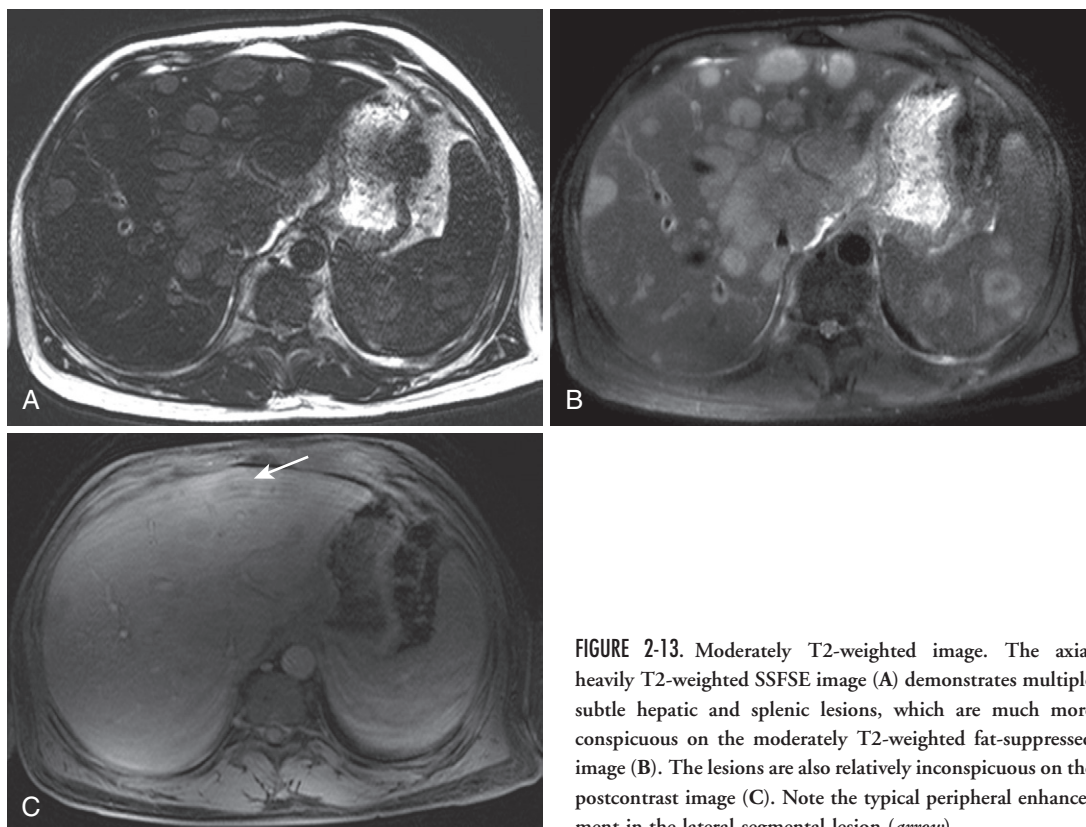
Moderately T2-weighted image. The axial heavily T2-weighted SSFSE image (A) demonstrates multiple subtle hepatic and splenic lesions, which are much more conspicuous on the moderately T2-weighted fat-suppressed image (B). The lesions are also relatively inconspicuous on the postcontrast image (C). Note the typical peripheral enhancement in the lateral segmental lesion (*arrow*).
